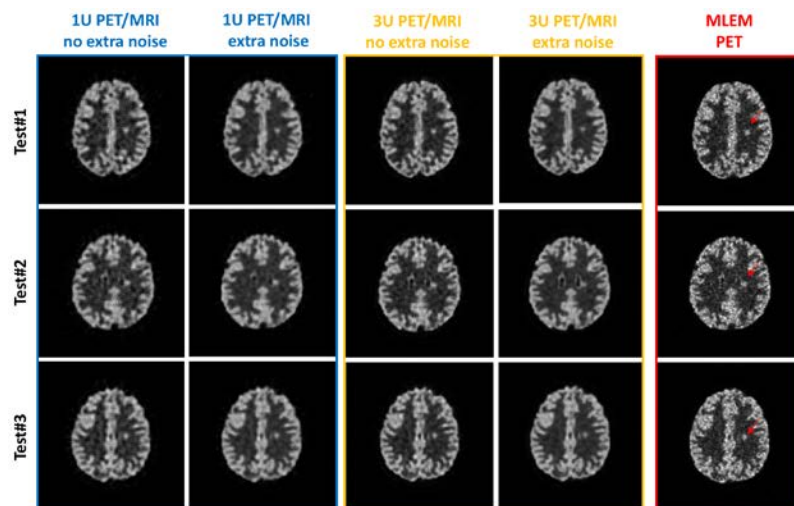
Inferences of three lesion test data. First two columns are 1U trained with PET/MRI without and with extra noise and the second two are 3U. The rightmost column is ML-EM reconstruction.
